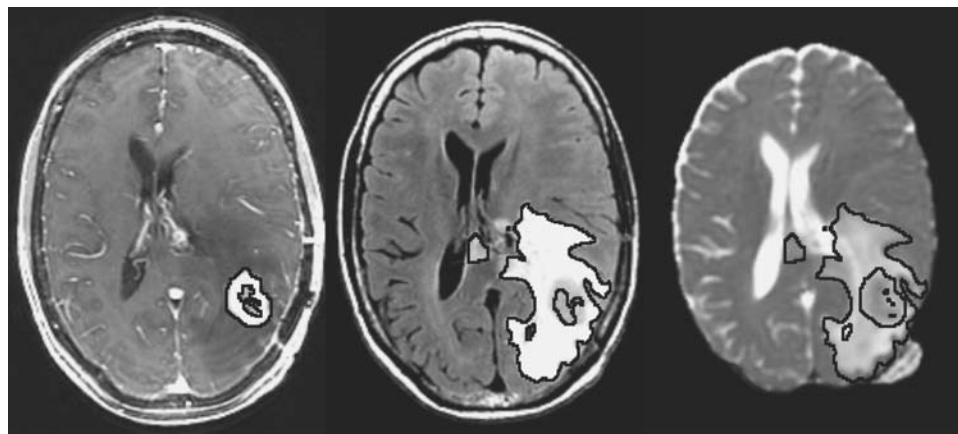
Axial T1-weighted postcontrast, FLAIR, and ADC maps from a patient with GBM. Lines represent CEL, T2ALL, and NEL contours, respectively.
